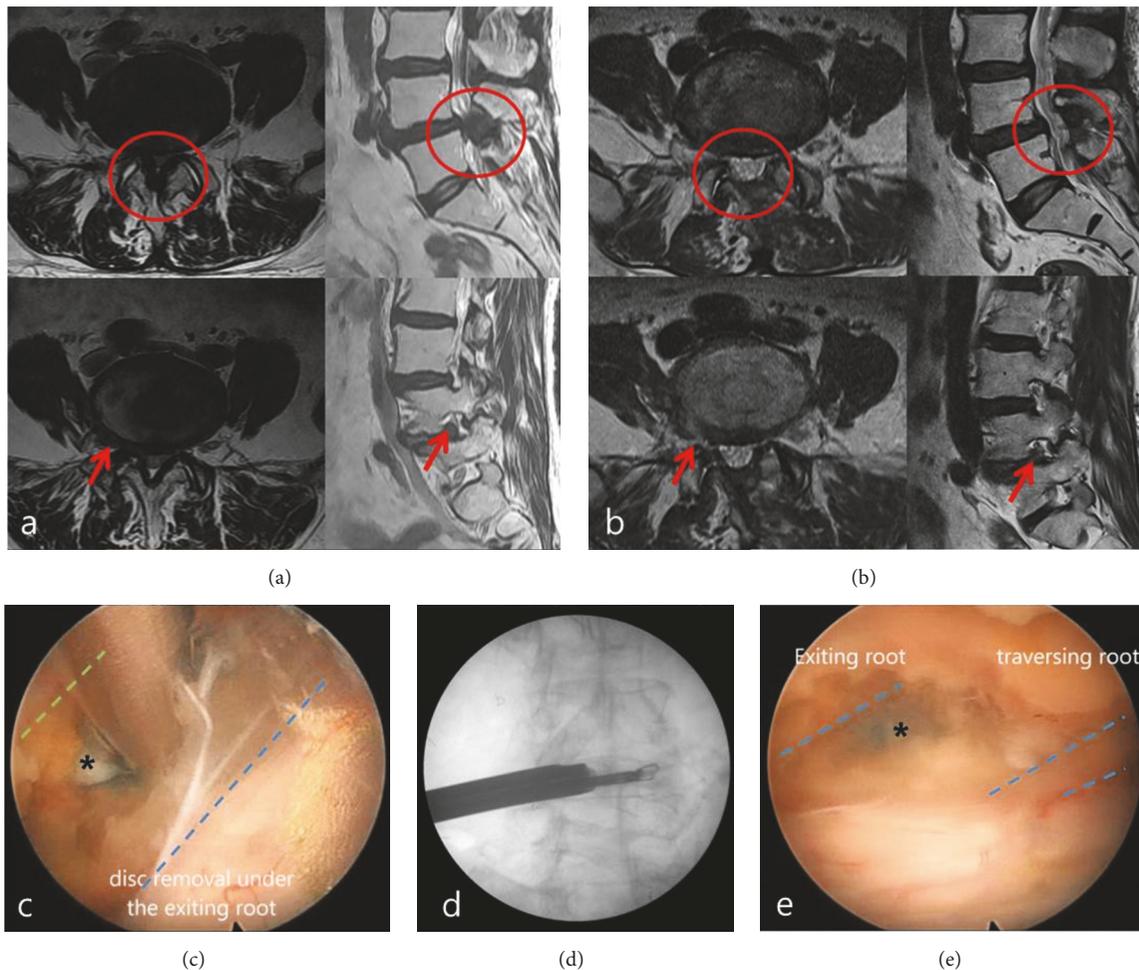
Extraforaminal disc herniation combined with central canal stenosis. (a) Preoperative sagittal and axial T2-weight MRI showing foraminal disc herniation combined with central canal stenosis. Red arrows: extraforaminal disc; red circle: stenotic region in spinal canal. (b) Postoperative axial and sagittal T2-weight MRI showing decompressed thecal sac and contralateral L4 root after removal of extraforaminal disc herniation at L4-5. Red arrows: decompressed area by removal of extraforaminal disc; red circle: enlarged spinal canal from preoperative stenosis. (c) Contralateral extraforaminal disc seen under the contralateral exiting root. Asterisk: ruptured extraforaminal disc; green dotted line: inferior margin of contralateral exiting root; blue dotted line: contralateral margin of thecal sac. (d) Intraoperative C-Arm image showing the location of forceps grasping protruded contralateral extraforaminal disc materials. (e) Decompressed both contralateral exiting and traversing root. Asterisk: removed site of extraforaminal disc. Blue dotted line: contralateral exiting and traversing root.
